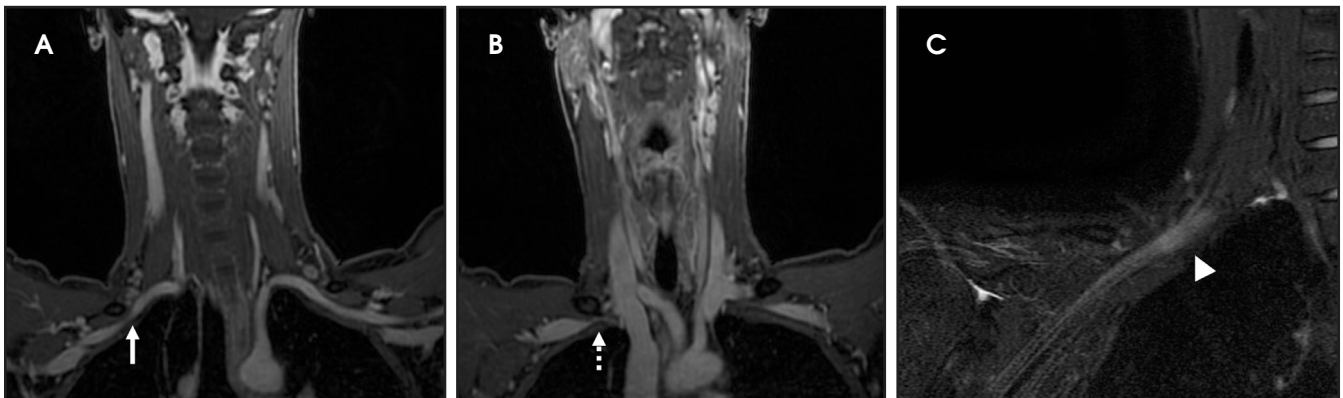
A 30-year-old woman with intermittent right arm swelling and pain. Contrast-enhanced MR angiography (A and B with arms raised) was performed using Time Resolved Imaging of Contrast KineticS (TRICKS) for suspected thoracic outlet syndrome. The arterial phase (A) shows narrowing of the right subclavian artery (solid arrow) at the costoclavicular space. Minimal narrowing of the contralateral left subclavian artery is also apparent. On the venous phase (B) there is narrowing of both subclavian veins, more marked on the right (dashed arrow) in the same region. Coronal T2W, fat-saturated MRI of the right brachial plexus (C) shows additional edema and enlargement of the trunks and proximal divisions of the brachial plexus (arrowhead), again at the costoclavicular space. No enlargement or edema of the nerves was noted on the left-side (images not shown). These findings were compatible with right-sided neurovascular thoracic outlet syndrome. There was an incomplete improvement with physical therapy, so the patient underwent external neurolysis of all the brachial plexus trunks, anterior and middle scalenectomy, and resection of the first rib. After 4 months follow-up there was >70% improvement and the patient resumed athletic activities.
